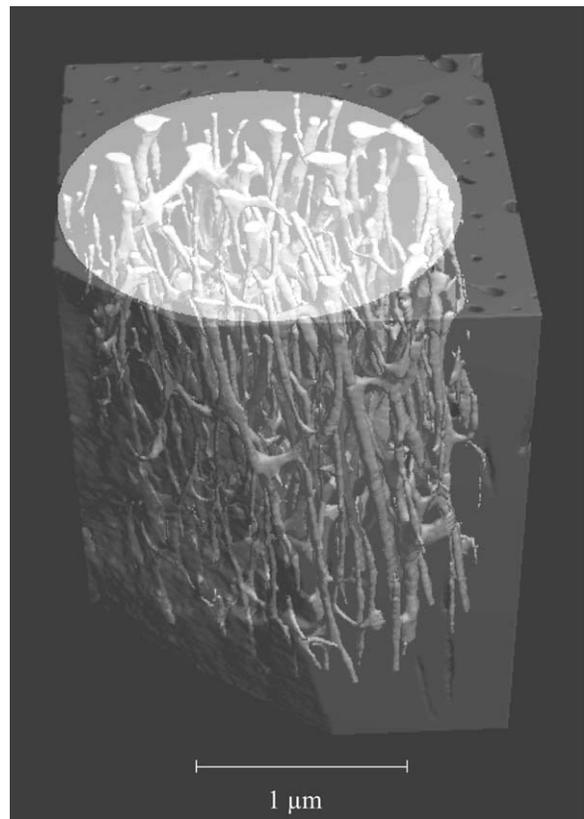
Individual X-rays are compiled into a 3D image, and then the colors assigned to bone and pore space are reversed, making the pore networks visible.
